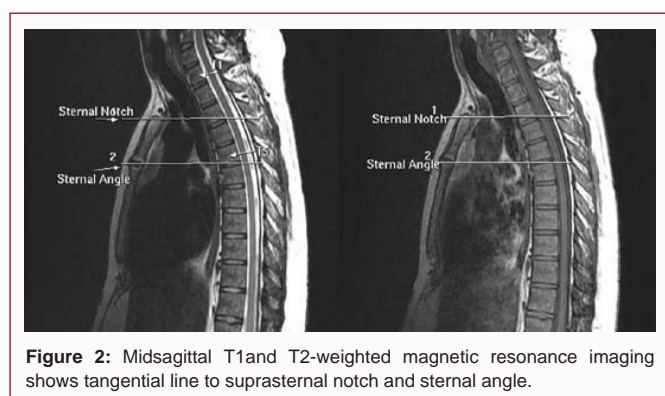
Midsagittal T1 and T2-weighted magnetic resonance imaging shows tangential line to suprasternal notch and sternal angle.
